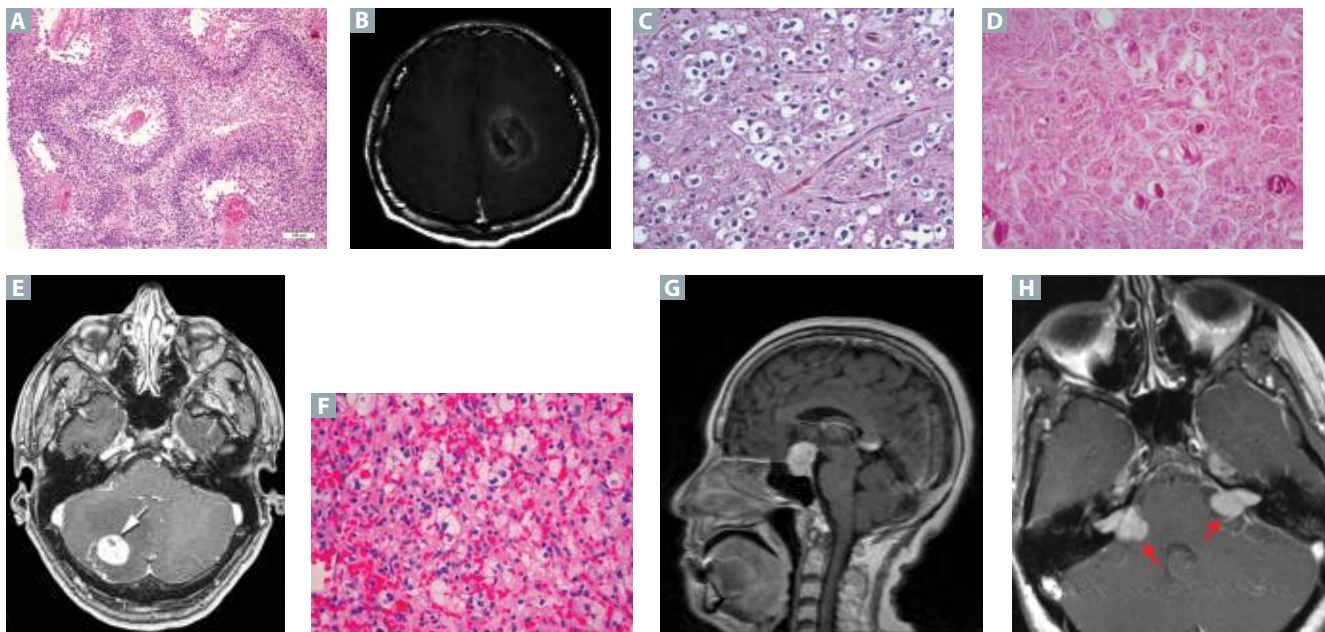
Image A reproduced with permission from Lim SM, Choi J, Chang JH, et al. Lack of ROS1 Gene Rearrangement in Glioblastoma Multiforme. *PLoS One*. 2015;10(9):e0137678. doi:10.1371/journal.pone.0137678. Image B reproduced with permission from Kao HW, Chiang SW, Chung HW, et al. Advanced MR imaging of gliomas: an update. *Biomed Res Int*. 2013;2013:970586. doi:10.1155/2013/970586. Image E reproduced with permission from Park DM, Zhuang Z, Chen L, et al. von Hippel-Lindau disease-associated hemangioblastomas are derived from embryologic multipotent cells. *PLoS Med*. 2007;4(2):e60. doi:10.1371/journal.pmed.0040060. Image F reproduced with permission from Zywicke H, Palmer CA, Vaphiades MS, Riley KO. Optic nerve hemangioblastoma: a case report. *Case Rep Pathol*. 2012;2012:915408. doi:10.1155/2012/915408. Image G reproduced with permission from Wang CS, Yeh TC, Wu TC, Yeh CH. Pituitary macroadenoma co-existent with supraclinoid internal carotid artery cerebral aneurysm: a case report and review of the literature. *Cases J*. 2009;2:6459. doi:10.4076/1757-1626-2-6459. Images C, D, and H reproduced with permission from USMLE-Rx.com.
